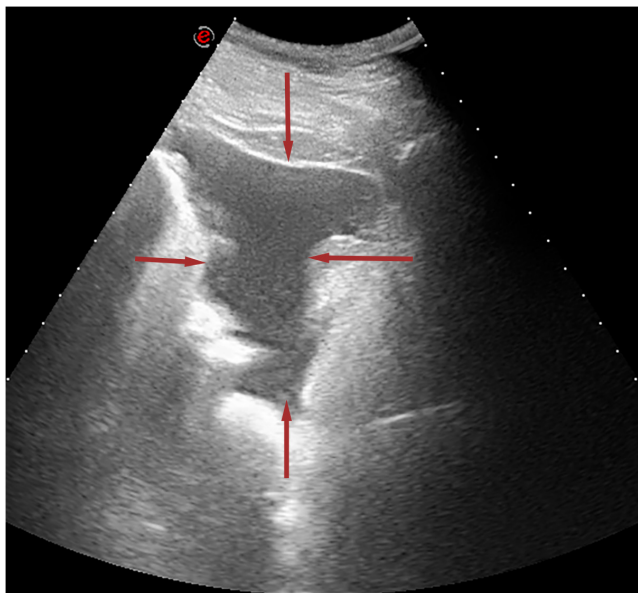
Grayscale sonogram of the liver with bedside color flow Doppler reveals perihepatic hematoma and intraperitoneal hemorrhage (arrow).
